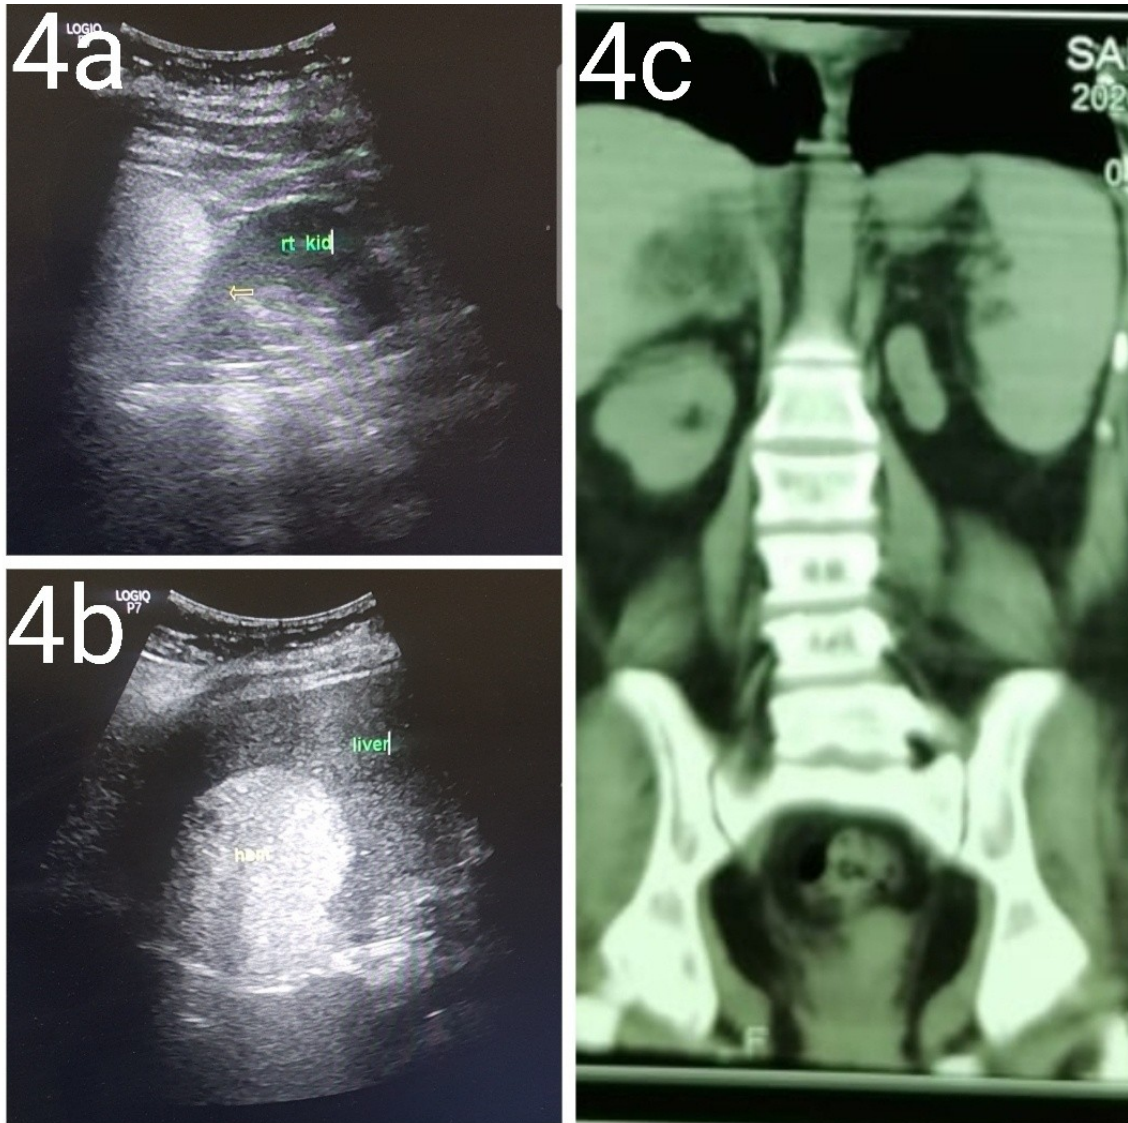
4a abdominal ultrasound showed small size right kidney 83*32 mm. 4b abdominal ultrasound showed enlarged liver with hyper echoic focal lesion in segment V (features of hepatic hemangioma). 4c CT-KUB showed atrophic left kidney.
